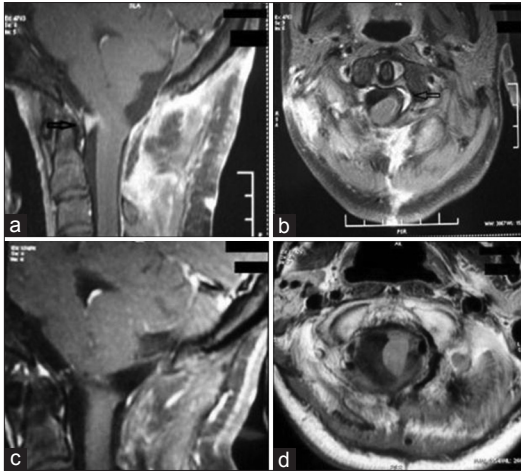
(a) Postoperative sagittal contrast-enhanced magnetic resonance imaging suggestive of enhancement ventral to brainstem (black arrow). (b) Postoperative axial contrast-enhanced magnetic resonance imaging suggestive of enhancement in the left side of brainstem. (c and d): 2-year postsurgery and postradiotherapy scan (sagittal and axial) showing no residual lesion or enhancement
